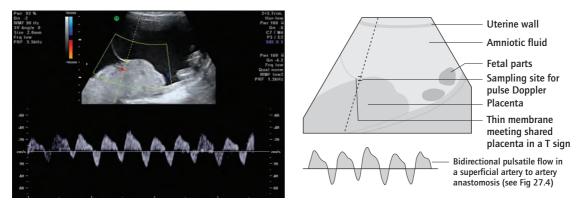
Ultrasound of monochorionic diamniotic twin placenta.
